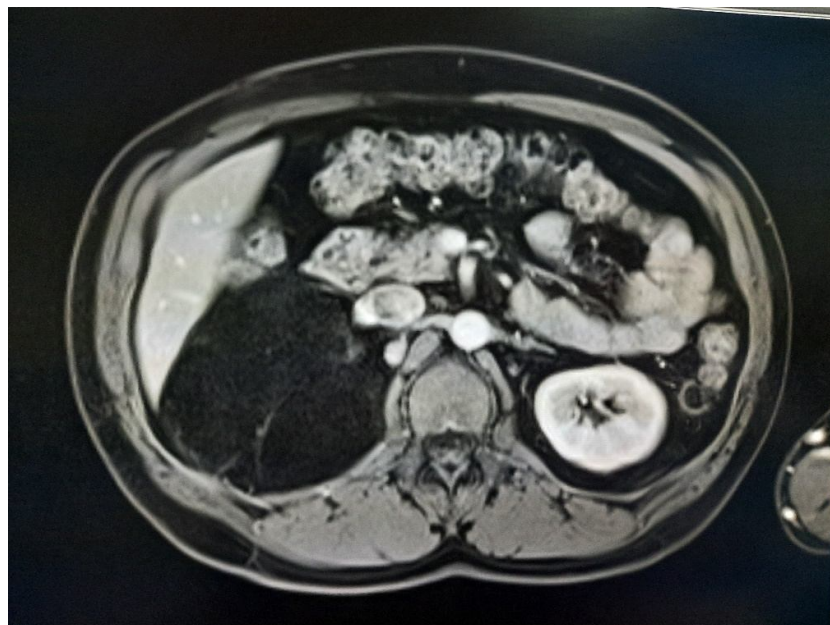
MRI with oval right adrenal mass
